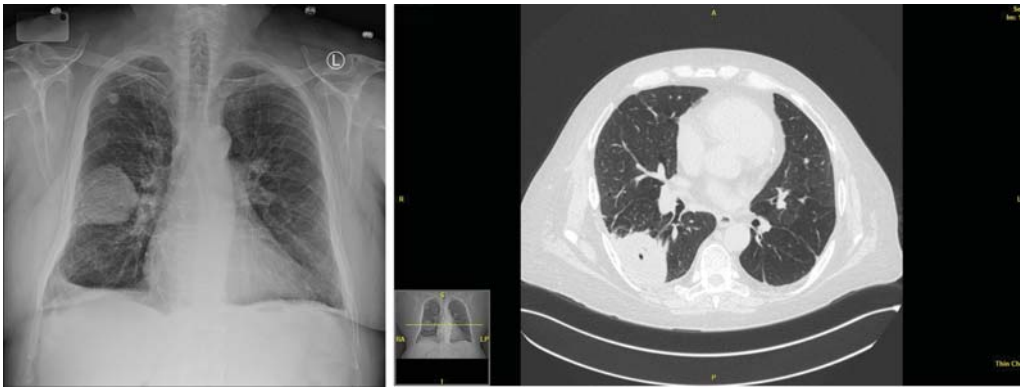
(A) Chest X-ray demonstrating a cavitary mass in the right lower lobe, biopsy proven to be an infection due to *Rhizopus* sp. (B) Partially cavitary mass in right lower lobe with adjacent pleural thickening, proven by biopsy to be *Rhizopus* sp.
